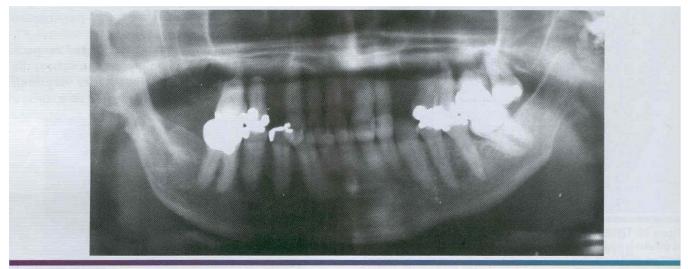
• Systemic sclerosis. Panoramic radiographic evaluation may show a characteristic resorption of the ramus, coronoid process, or condyle.
